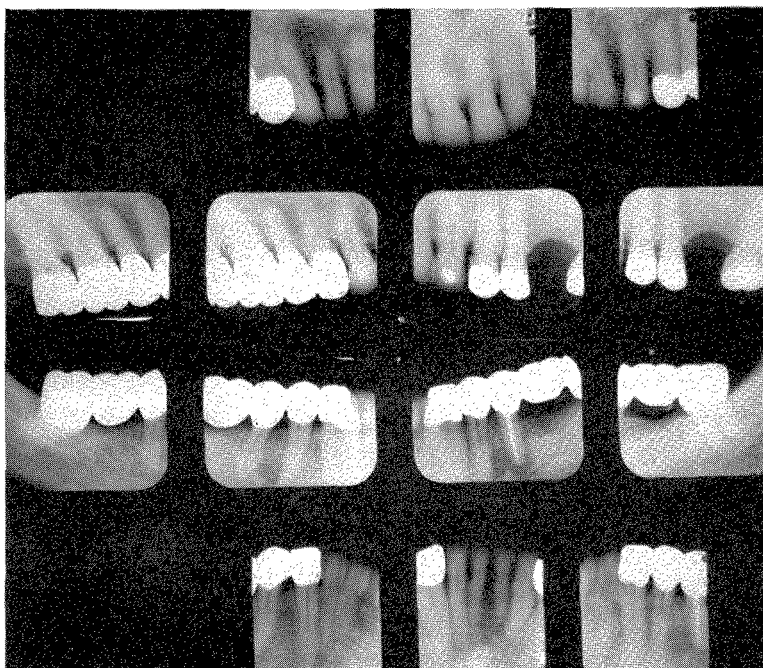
Roentgenograms taken in 1962 of the case shown in Figs. 731 to 737.
